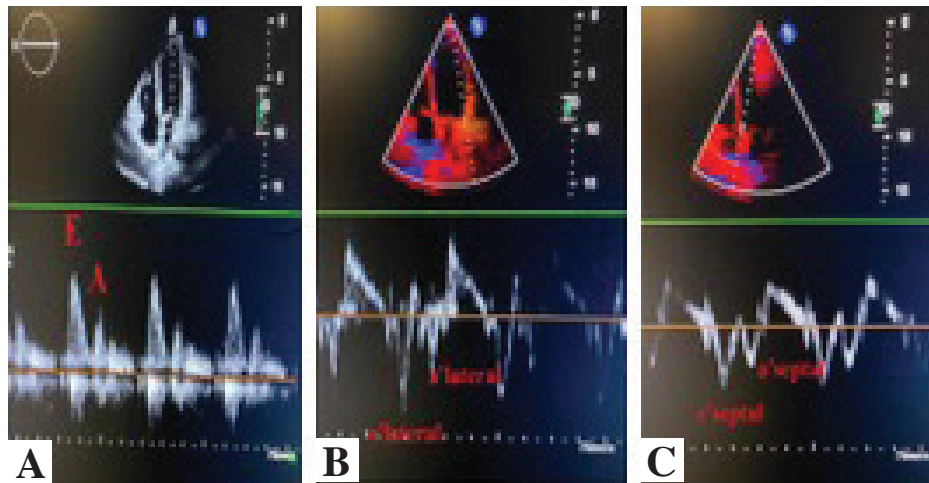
Mitral inflow and tissue Doppler velocities measurements. A: Mitral inflow velocities, B: Lateral tissue Doppler velocities of the mitral annulus, C: Septal tissue Doppler velocities of the mitral annulus.
